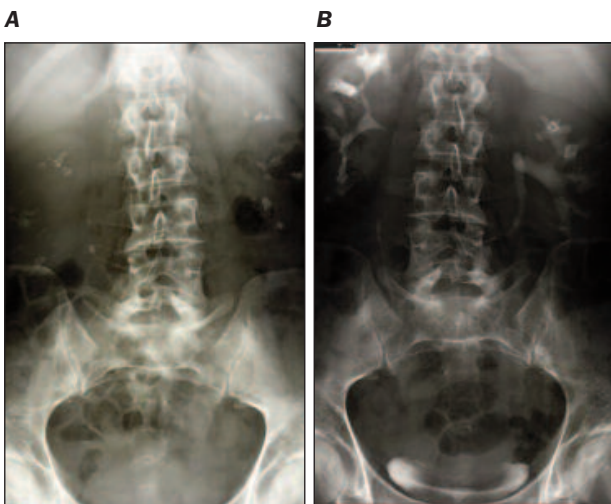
Woman 57 yrs old affected by recurrent calcium nephrolithiasis. A, B, X-Ray plus urogram performed before the start of treatment with potassium citrate (6 g per day orally in 3 doses). C, X-Ray after 6 yrs continuous therapy. Most of the left kidney stones disappeared asymptotically, while for the right ureteral stone ureteroscopy was required.
